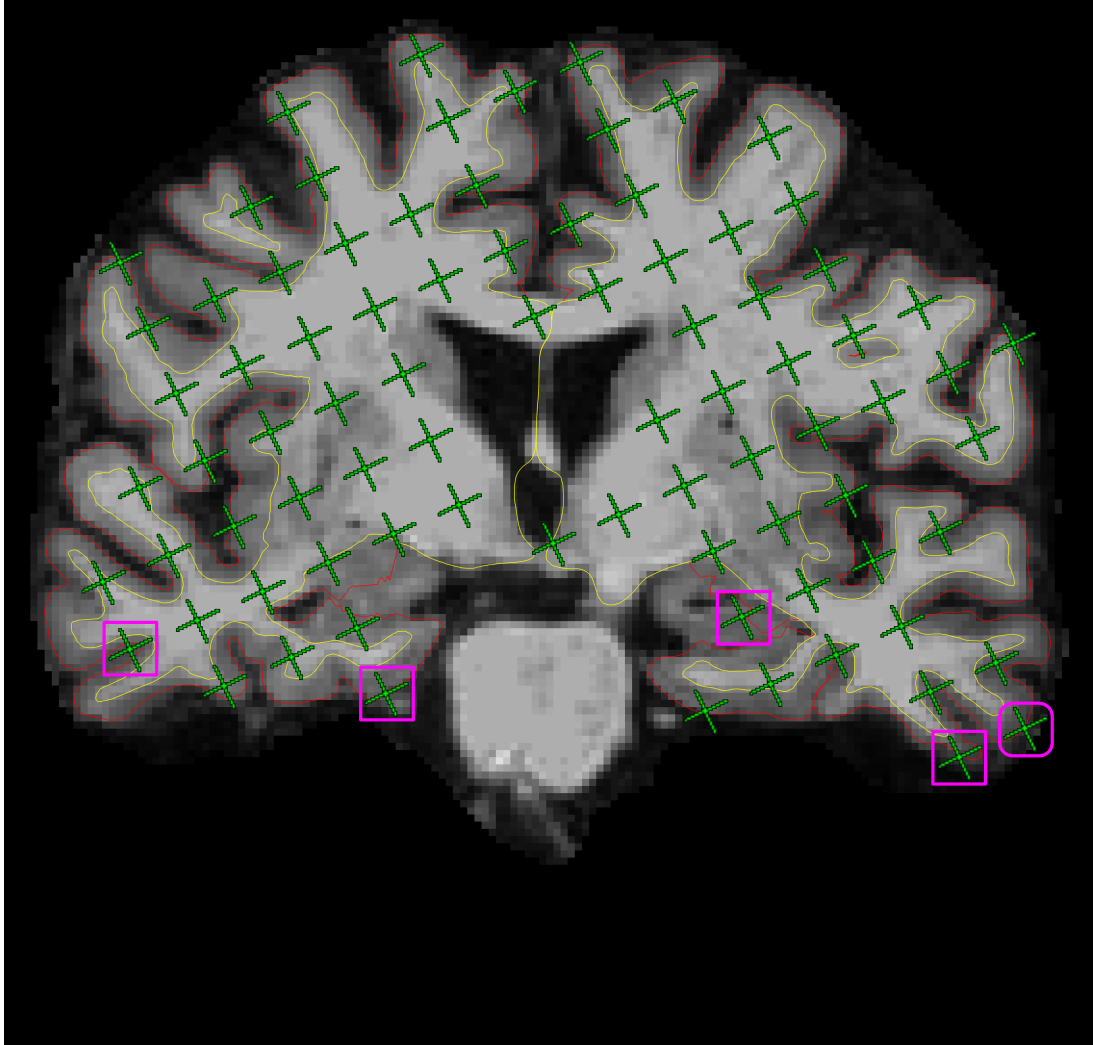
On the 10th slice of one brain MR image in the coronal view, counted test points (green) hitting the cerebrum (excluding ventricles) are overlaid onto pial profiles (red lines) segmented by `FREESURFER`. Rectangles (pink) mark the counted test points which fall outside the grey matter boundaries (red lines) and rounded rectangles (pink, racetrack-like) mark the test points hitting exactly on the grey matter boundaries.
